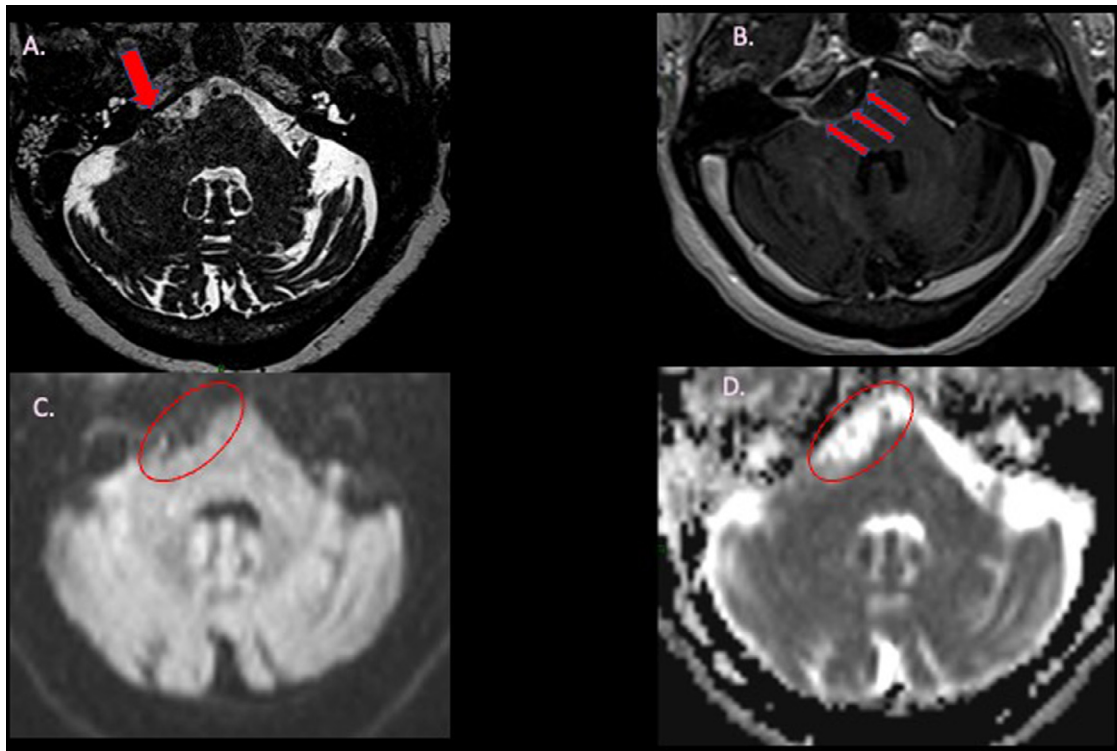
(A) Axial balanced steady-state sequence shows a cystic lesion of the right CPA, containing a blood-fluid level (red arrow). (B) T1-weighted post-contrast axial images show peripheral enhancement (red arrows). (C) DWI axial images and (D) the ADC map show absent diffusion restriction (red circles).
